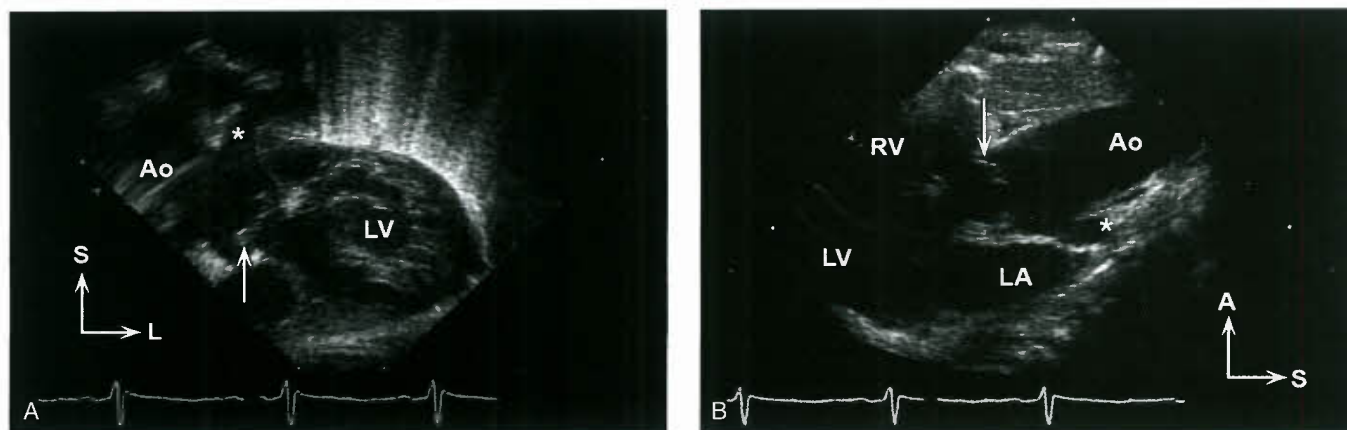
A: Subcostal coronal view with anterior angulation in newborn with truncus arteriosus type I and moderately severe truncal regurgitation. Arrow indicates doming, thickened truncal valve; aortic root (Ao) continues anteriorly/superiorly. Origin of the pulmonary trunk indicated by the asterisk. L, left; LV, left ventricle; S, superior. B: High parasternal long-axis view in same newborn with truncus arteriosus type I, with the doming truncal valve (arrow) and posterior origin of the pulmonary trunk (asterisk). A, anterior; LA, left atrium; LV, left ventricle; RV, right ventricle; S, superior.
